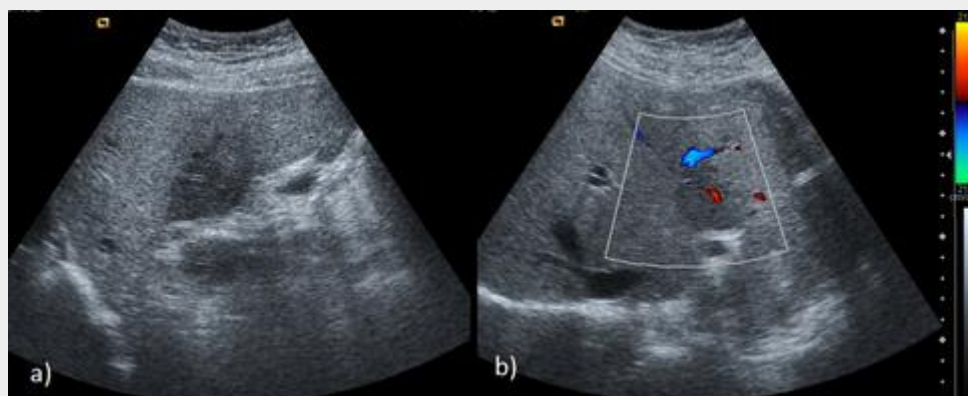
Ultrasound images showing a hypoechoic area in the left lobe (a); no vessel distortion is shown in Doppler study (b); these are characteristic features of FFS area. No enhancing lesion was found in CT study (not shown).
